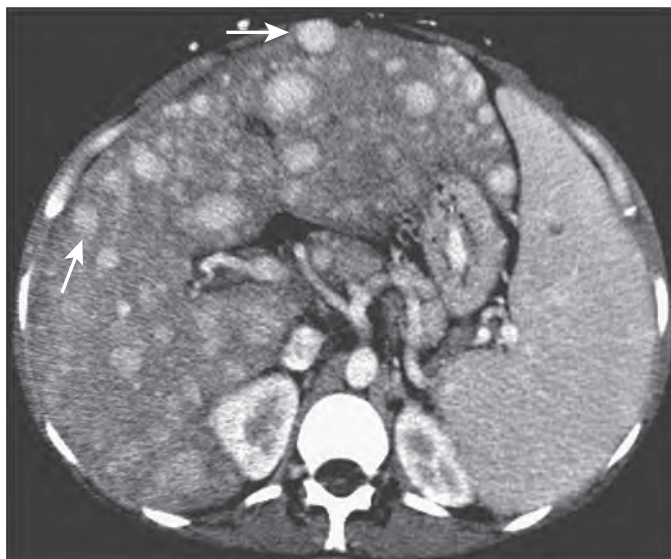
Budd-Chiari syndrome: nodular regenerative hyperplasia. Multiple hypervascular lesions (arrows) are identified on contrast-enhanced CT. (Case courtesy Michael P. Federle, MD, Stanford University.)
